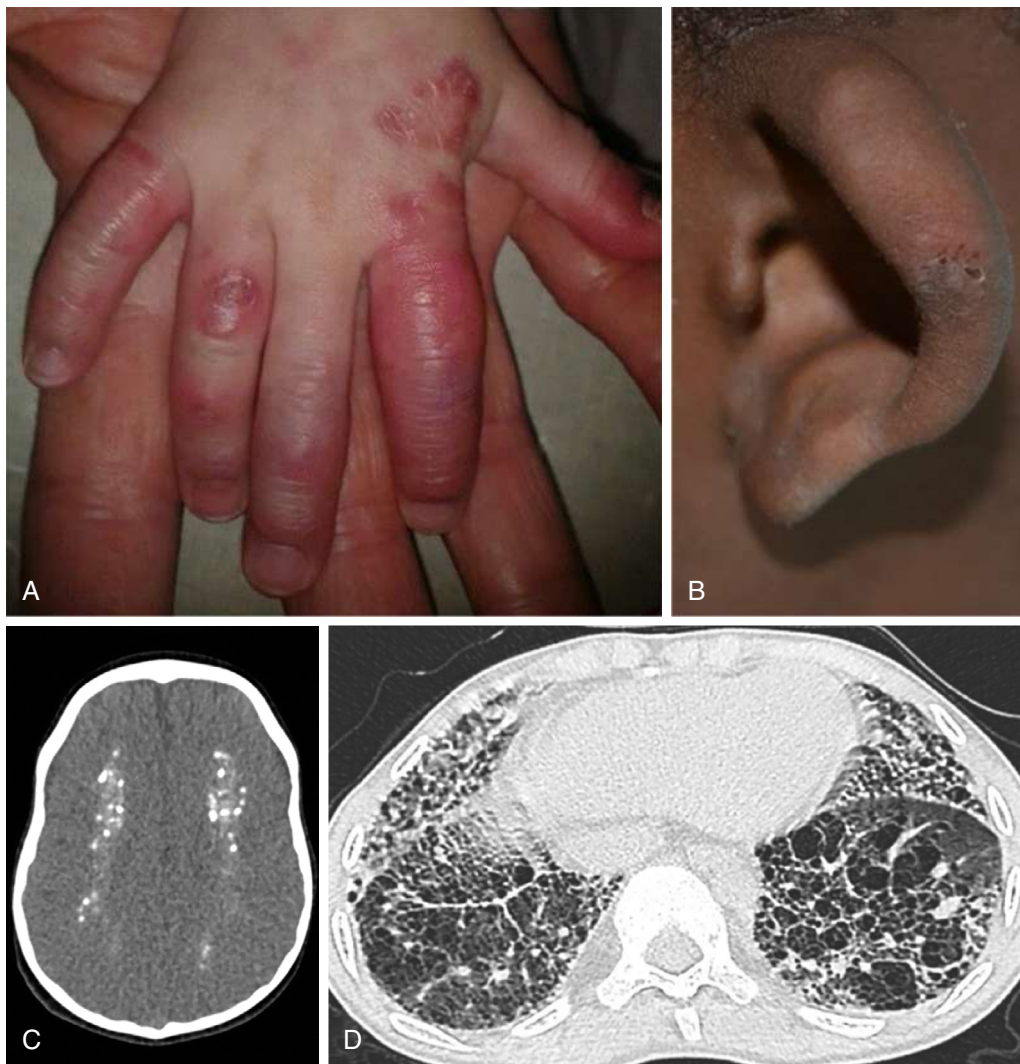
Characteristic clinical phenotypes of interferonopathies. Chilblain lesions typical of monogenic type I interferonopathies, seen most frequently on the toes, fingers (A), ears (B), and nose. The lesions are generally worse in the cold months. C, Representative brain CT scan of intracranial calcifications seen in a patient with Aicardi-Goutières syndrome due to *TREX1* homozygous pathogenic variants. D, Chest CT scan of a SAVI patient (performed at the age of 12.5 years) showing evidence of interstitial lung disease (interlobular septal thickening, intralobular lines, cystic lesions, and some ground-glass lesions) and fibrosis (honeycombing). (Modified from Melki I, Fremont ML. Type I interferonopathies: from a novel concept to targeted therapeutics. *Curr Rheum Reports*. 2020;22:32, Fig. 1.)
